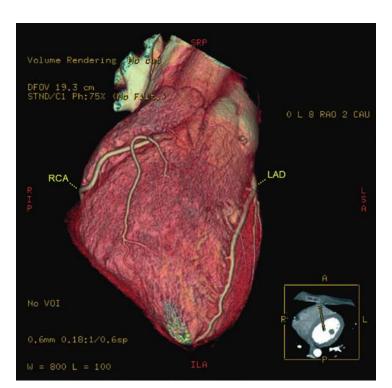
Three-dimensional volume-rendering reconstruction of the heart in a pediatric patient, showing normal coronary arteries as demonstrated with a 64-slice multidetector spiral CT scanner. A, Anterior; I, inferior; L, left; LAD, left anterior descending artery; P, posterior; R, right; RCA, right coronary artery; S, superior.
